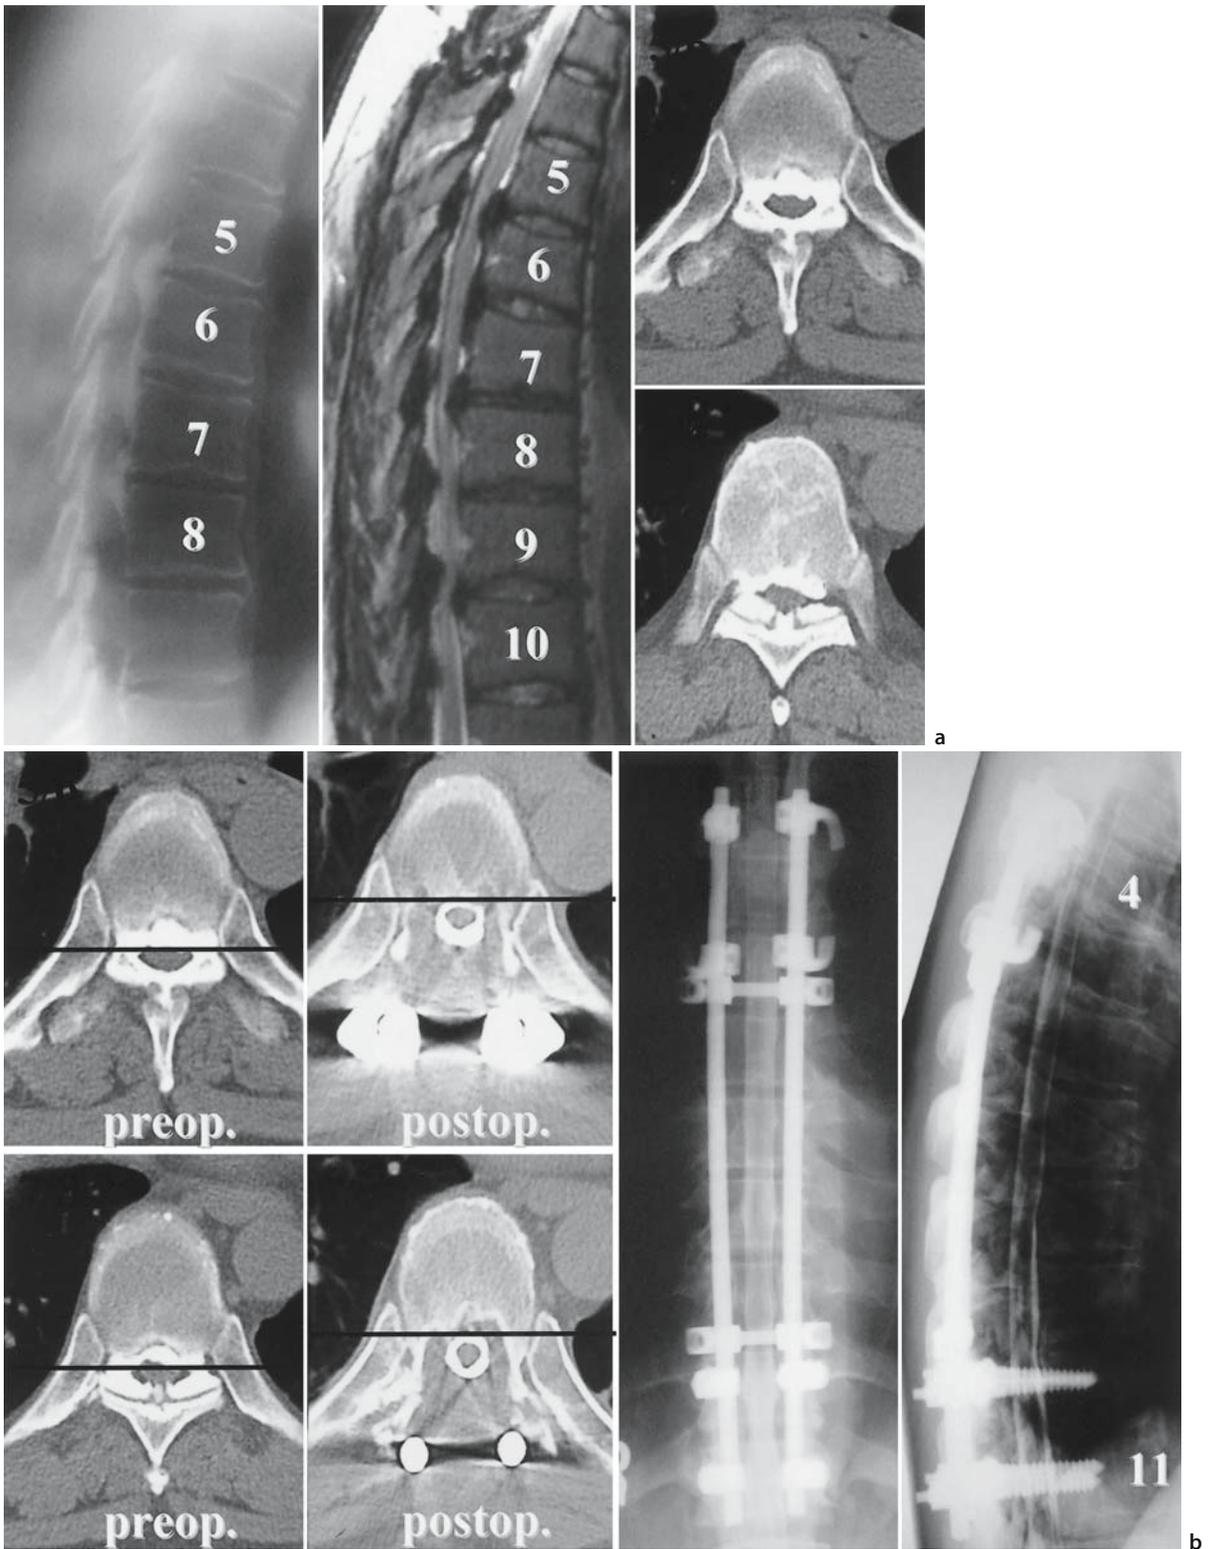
a Patient with spinal cord compression due to OPLL and OLF. b Preoperative and postoperative CT scans demonstrate successful extirpation of the ossified ligament and the anterior shift of the spinal cord. The preoperative Japanese
